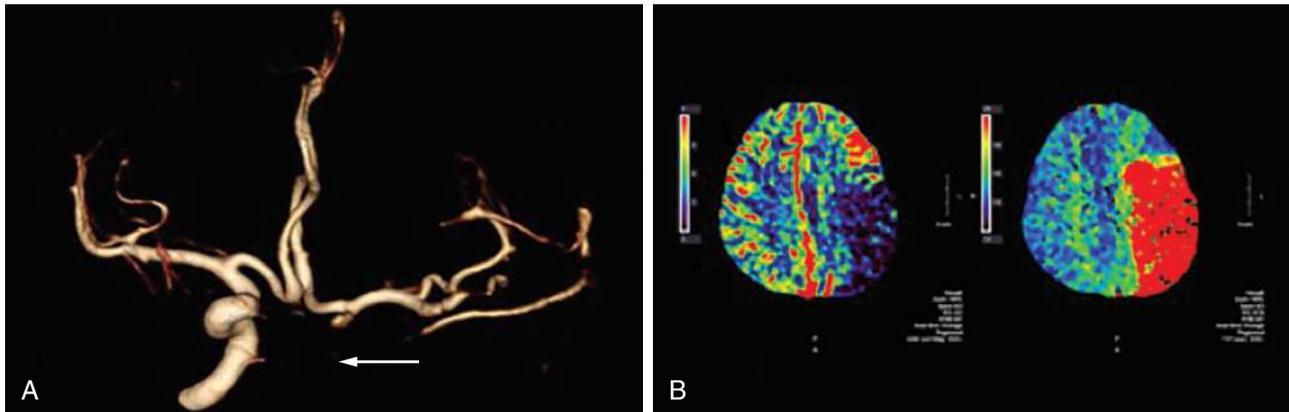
CT angiography and perfusion imaging in acute infarction. A, Volume-rendered reconstruction of a CT angiogram shows absence of the cavernous and supraclinoid segments of the left internal carotid artery (*white arrow*) secondary to thrombotic occlusion. The left ACA and MCA partially fill via collateral flow through the anterior communicating artery. B, CT perfusion maps show increased time-to-peak enhancement (*right*) and decreased cerebral blood volume (*left*) in the left MCA territory consistent with core infarction and irreversible ischemia.
